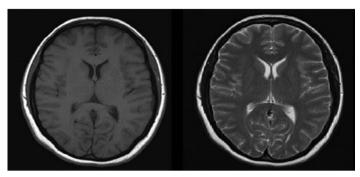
T1 versus T2 MRI.
